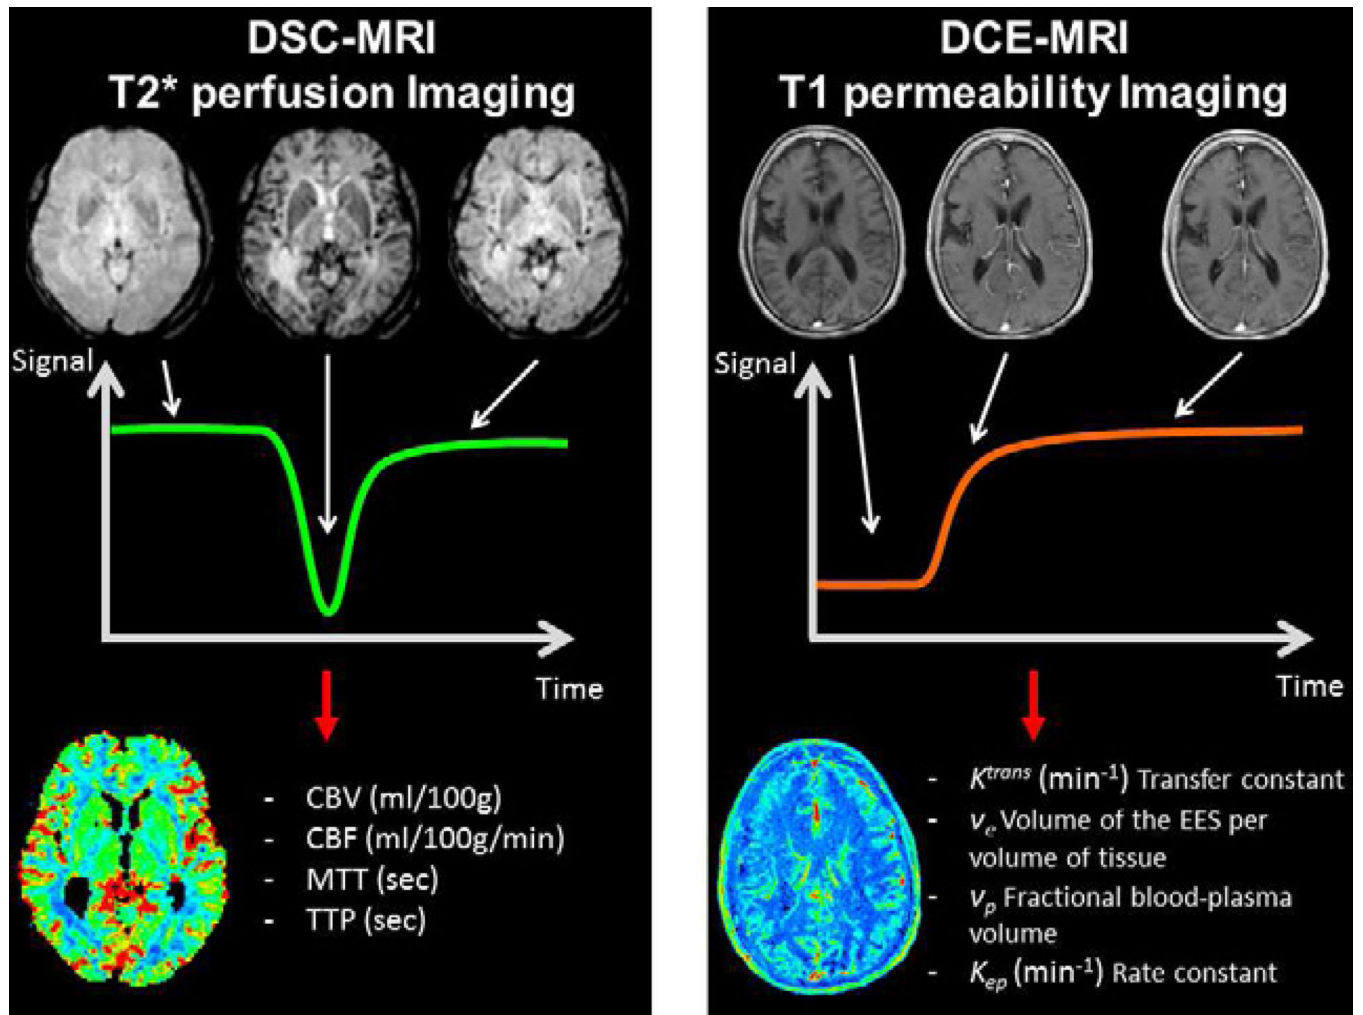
Dynamic susceptibility contrast imaging (DSC-MRI)- left column- and dynamic contrast-enhanced MRI imaging (DCE-MRI) - right column- principles overview. Sample time series images during the passage of the contrast agent - first row- and the resulting time signal course - second row. The image processing based on the time curve allows to extract qualitative or quantitative metrics of perfusion (DSC-MRI) and/or permeability (DCE-MRI) and obtain parametric maps.
